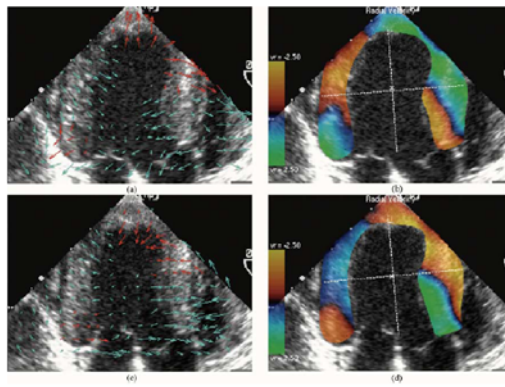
Echocardiograms with superimposed motion information after infarction. (a) Estimated velocity field during systole. (b) Color-coded radial velocity during systole. (c) Velocity field during diastole. (d) Color-coded radial velocity during diastole. Regions with abnormal wall motion (dyskinesia) are highlighted by red arrows. The principal axes of inertia of the ROI are indicated by dotted lines. Reprinted, with permission, from [50], © 2005 IEEE.
